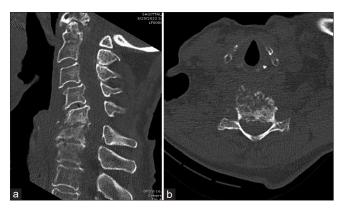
(a) A sagittal computed tomography scan of the cervical spine shows an acute anterior wedge compression fracture at C6 with associated C5-6 disc space collapse and endplate destruction. Kyphotic alignment and chronic C3-4 anterolisthesis are noted. (b) An axial computed tomography scan of the cervical spine at the C5-6 disc space level shows endplate destruction.
